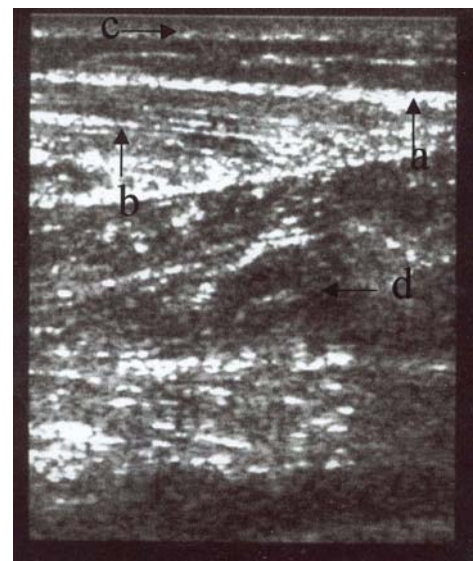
The gray scale ultrasonogram of legs edema result from venous disease
